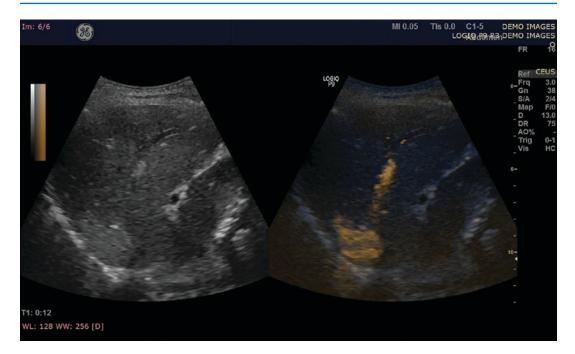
Contrast-enhanced ultrasonography imaging of liver
